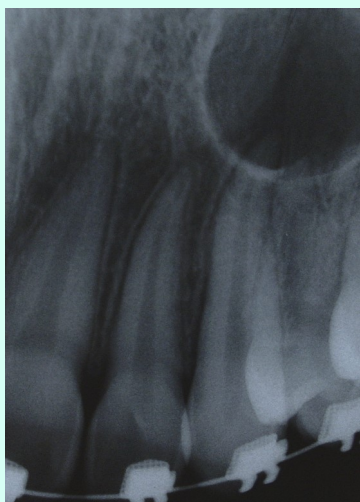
Radiolucent image on periapical radiograph.
